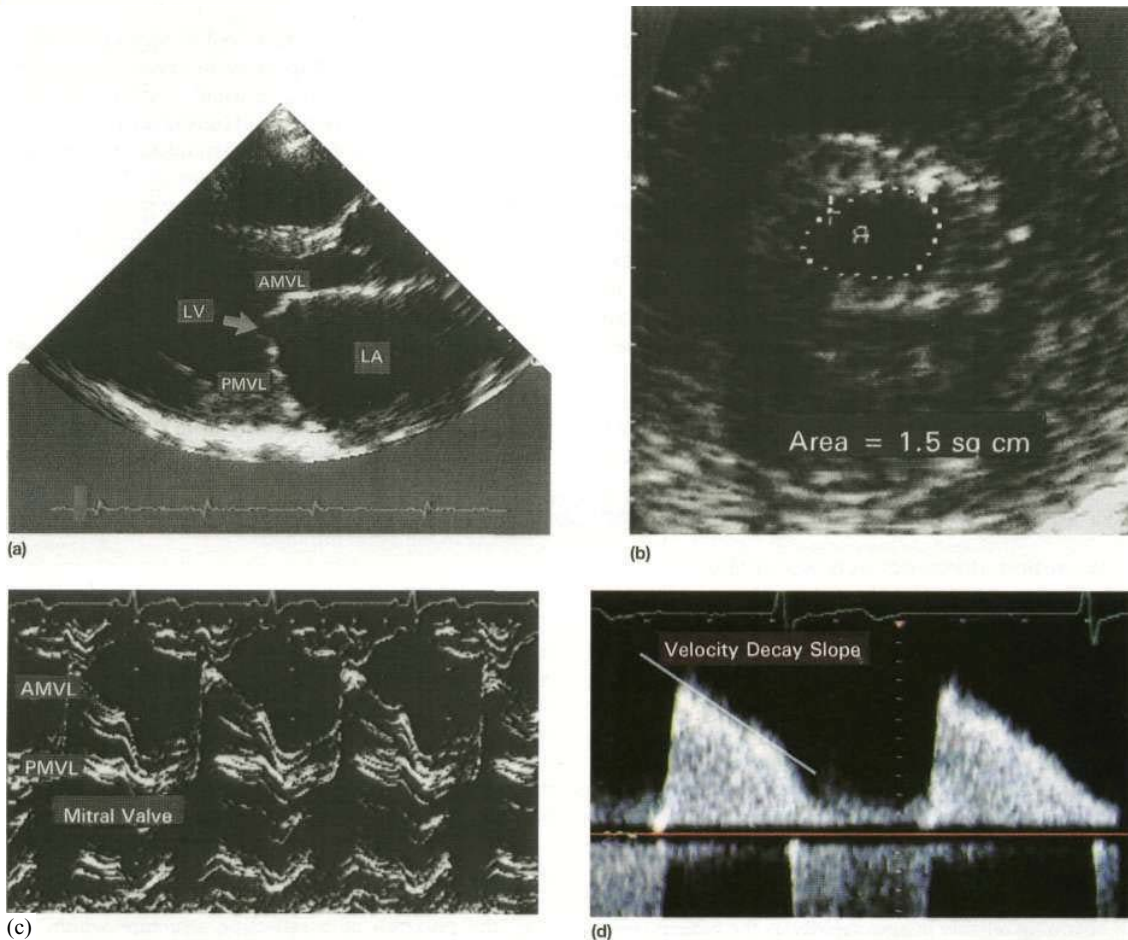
Echocardiograms in rheumatic mitral valve disease, (a) Two-dimensional long-axis view showing enlarged left atrium and 'hooked' appearance of the mitral valve leaflets resulting from commissural fusion. (b) Magnified short-axis view showing the mitral valve orifice as seen from the direction of the arrow in (a). The orifice area can be planimetered to assess the severity; in this case it is 1.5 cm^2 , indicating moderately severe disease. (c) M-mode recording of the mitral valve showing restricted motion of the thickened leaflets. (d) Continuous-wave (CW) Doppler recording showing slow rate of decay of flow velocity from the left atrium to the left ventricle during diastole. It is also possible to derive the valve orifice area from the velocity decay rate. LA, left atrium; LV, left ventricle; AMVL, PMVL, anterior and posterior mitral valve leaflets.
